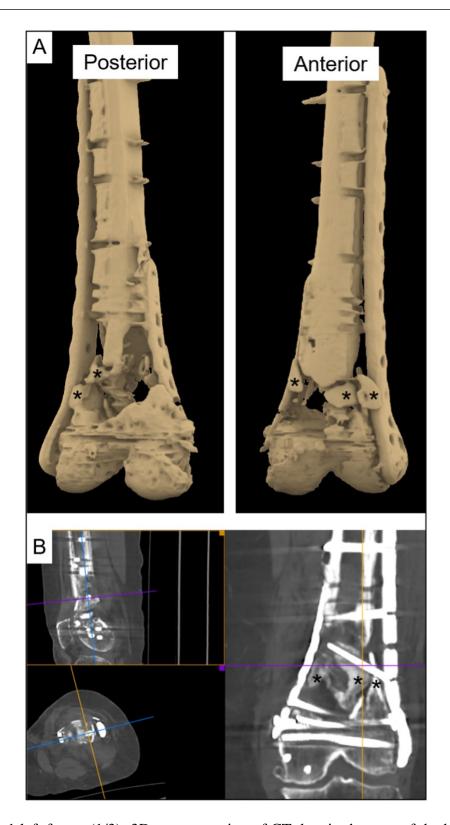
Case 1 left femur (1/3): 3D reconstruction of CT data in the area of the bone defect in the area of the distal left femur showed sclerosed and necrotic bone fragments (A). Furthermore, the CT analysis showed several screws in the area of the bone defect, which therefore no longer contributed to the biomechanical stabilization (B). Asterisks (*) indicate sclerotic/necrotic bone.
